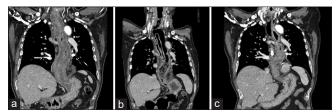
Computed tomography scans. (a) The esophagus with submucosal swelling. (b) The esophagus with submucosal air-fluid and dissection. (c) The reattachment of the mucosa to the muscle layer with minimal residual abscess
